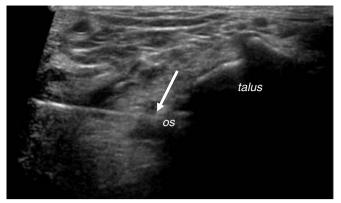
Short axis image from ultrasound-guided injection demonstrates the needle tip abutting the os trigonum (*arrow*). The os trigonum and adjacent talus are labeled for reference
